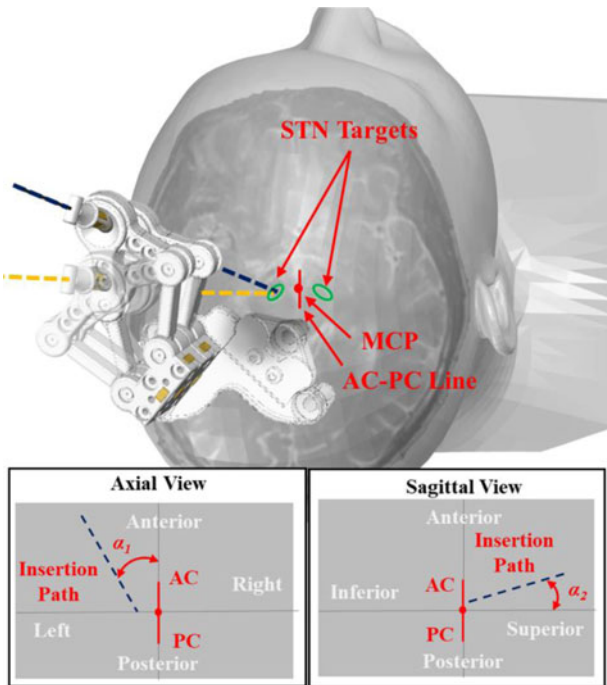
A single manipulator shown with two possible configurations. Boundaries of STN targets highlighted in green, which could be revealed by T2-weighted MRI. The insertion path is the pre-operatively planned trajectory. Its angular inclinations (α_1 and α_2) and projection at axial/sagittal planes are shown in the block at lower left and lower right corner, respectively.
